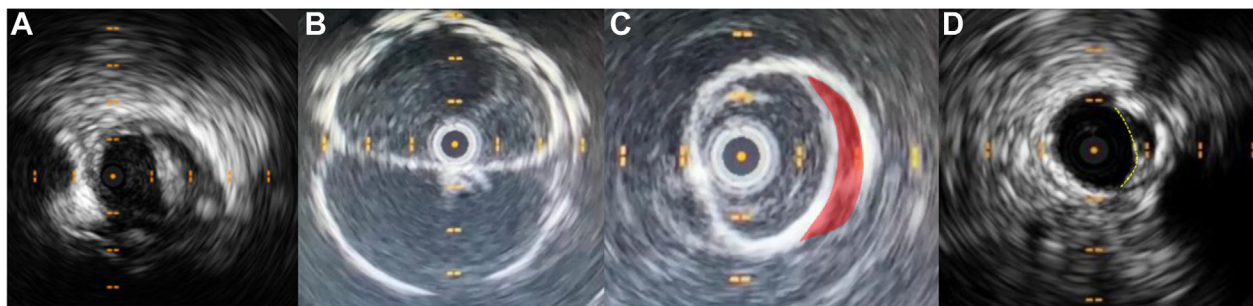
Intravascular ultrasound (IVUS) technical assessment. A, Presence of residual stenosis at the level of the distal landing site in the external iliac artery. B, Evaluation of the conformation of the two kissing stents. Note the symmetric D-shape morphology. C, Inadequate stent-to-arterial wall apposition in a common iliac stent (red area). D, Residual dissection at the level of the distal edge of the stent in the common iliac artery.
